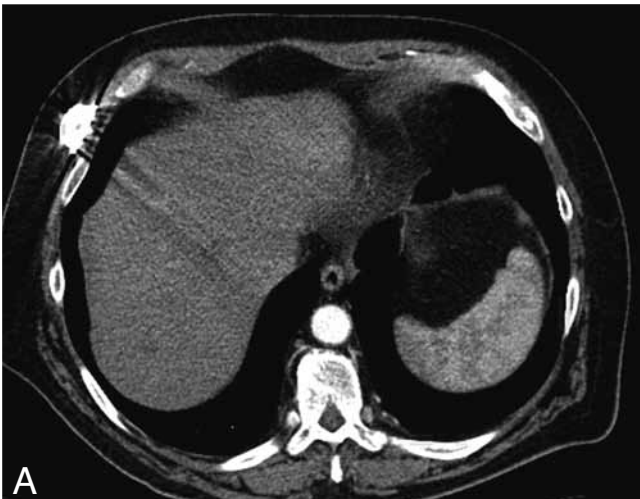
Biphasic contrast-enhanced CT scan in a patient with colo-rectal liver metastases. A. Arterial-phase scan does not show liver metastases. Artifacts are due to arterial port. B. The venous-phase image clearly demonstrates three hypodense metastases.
